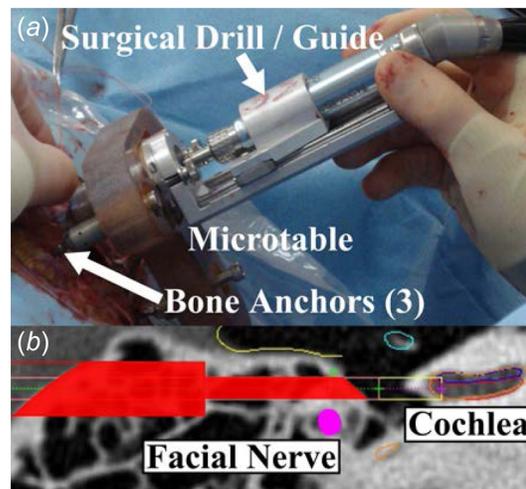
(a) Less invasive CI surgical system consisting of a microtable and drill guide attached to the patient's skull and (b) CT scan showing two-stage drill path to cochlea passing close to facial nerve
